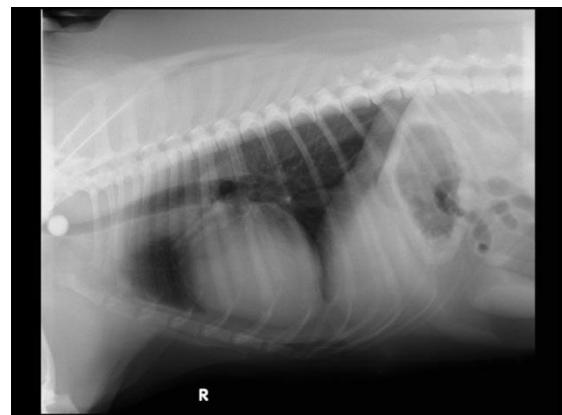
Lateral view thoracic radiograph was performed to define the location of foreign body prior to surgery and the radiographs showed a foreign body slipped from the proximal to the intra-thoracic part of trachea.
